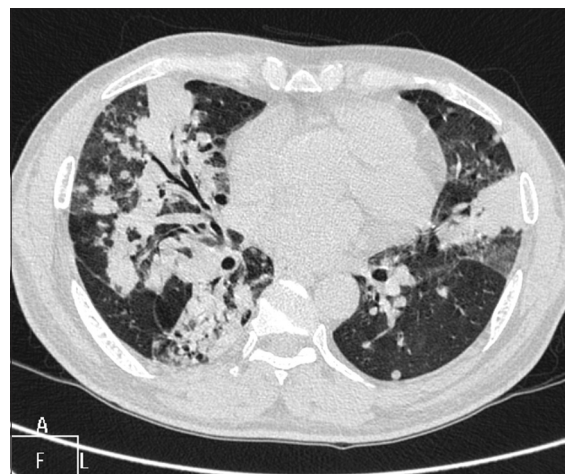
Contrast enhanced computed tomography thorax showing the lung window
